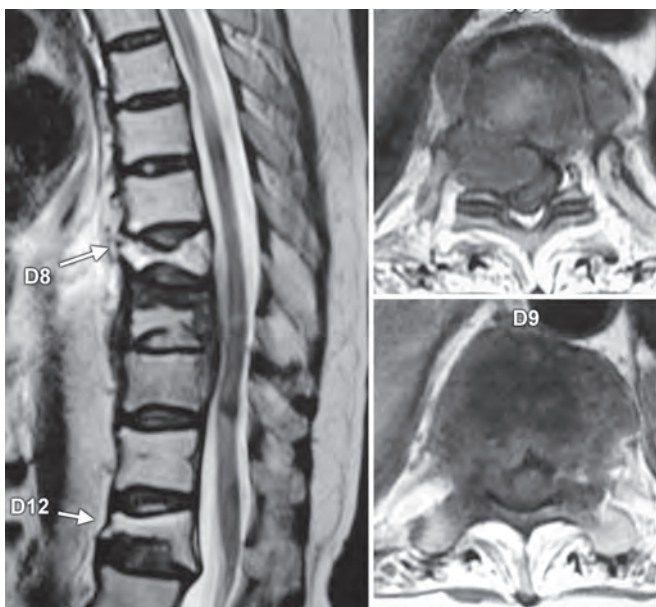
MRI of the dorsolumbar spine of a patient treated for breast carcinoma showing multiple vertebral lesions with soft tissue component causing compression of the spinal cord suggestive of metastatic deposit
